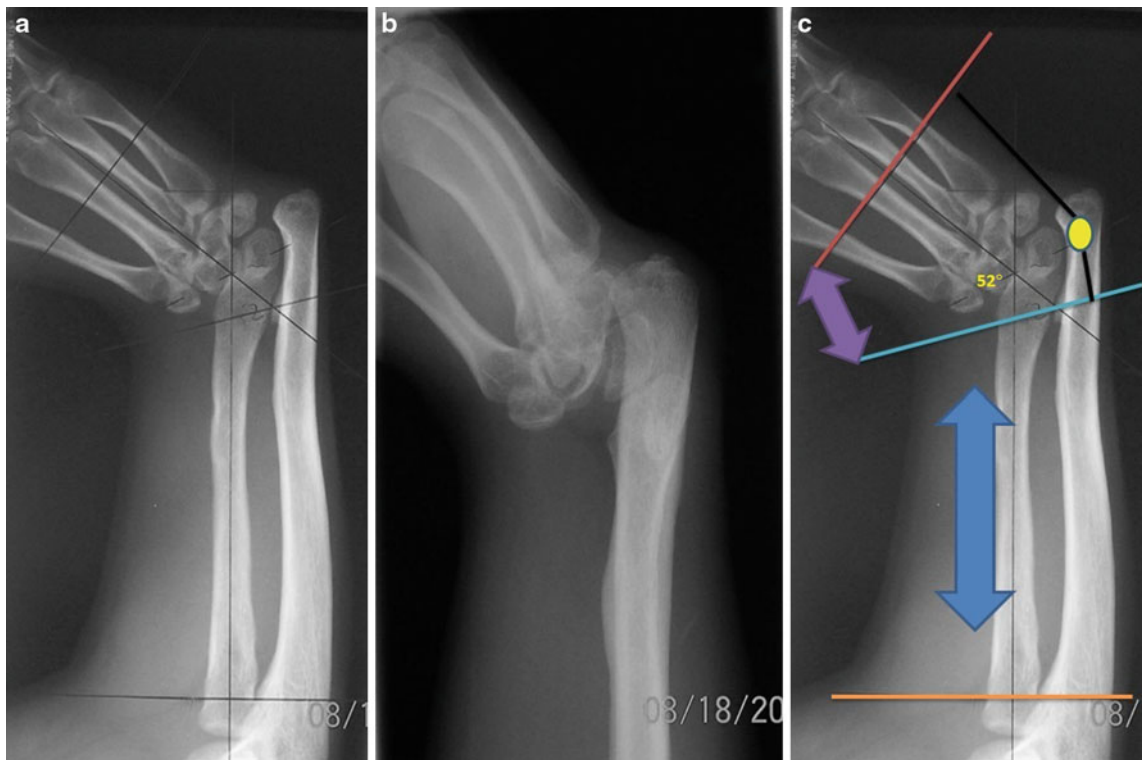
Preoperative X-rays. (a) AP of the wrist showing 52° of radial deviation of the hand and short radius relative to the ulna. (b) Lateral X-ray showing palmar translation of the hand. (c) Surgical planning: proximal ring (orange line); distal radius ring (blue line); distraction
